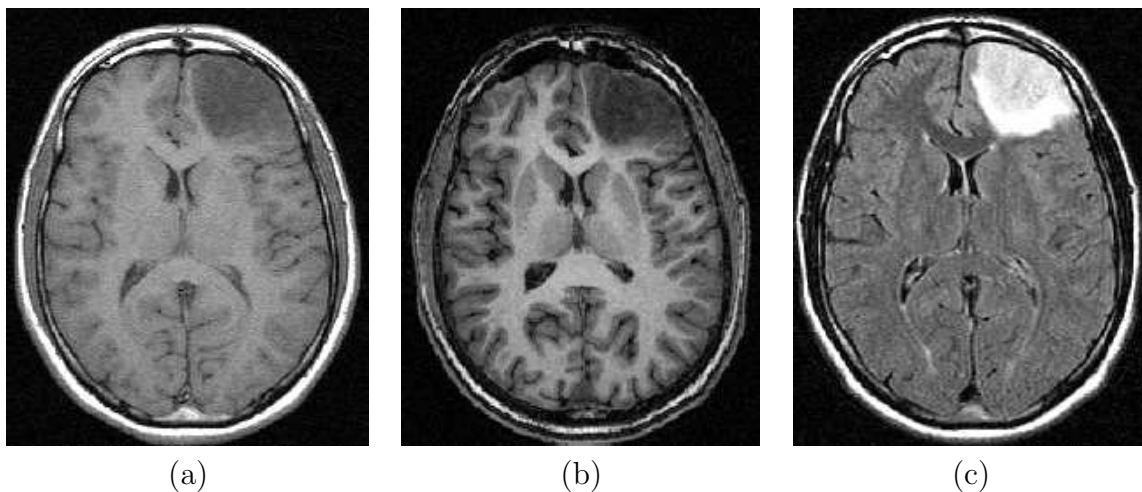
A non-enhanced tumor. a) Axial slice of T1-weighted. b) The same slice of contrast enhanced T1-weighted. c) FLAIR image.
